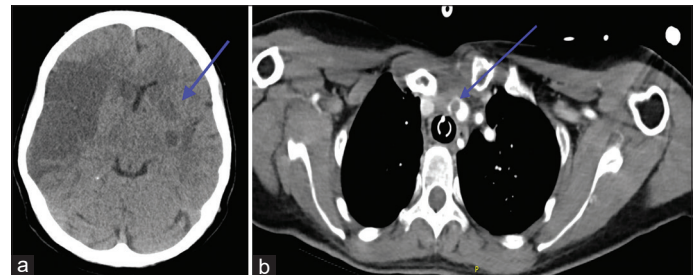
(a) Non-contrast computed tomography brain revealing established dense right-sided infarct with multiple new areas of low attenuation in the left head of caudate, basal ganglia, and insular cortex and (b) filling defect within the arch of the aorta and soft-tissue mass anteriorly invading the vessel with extensive tumor thrombus
